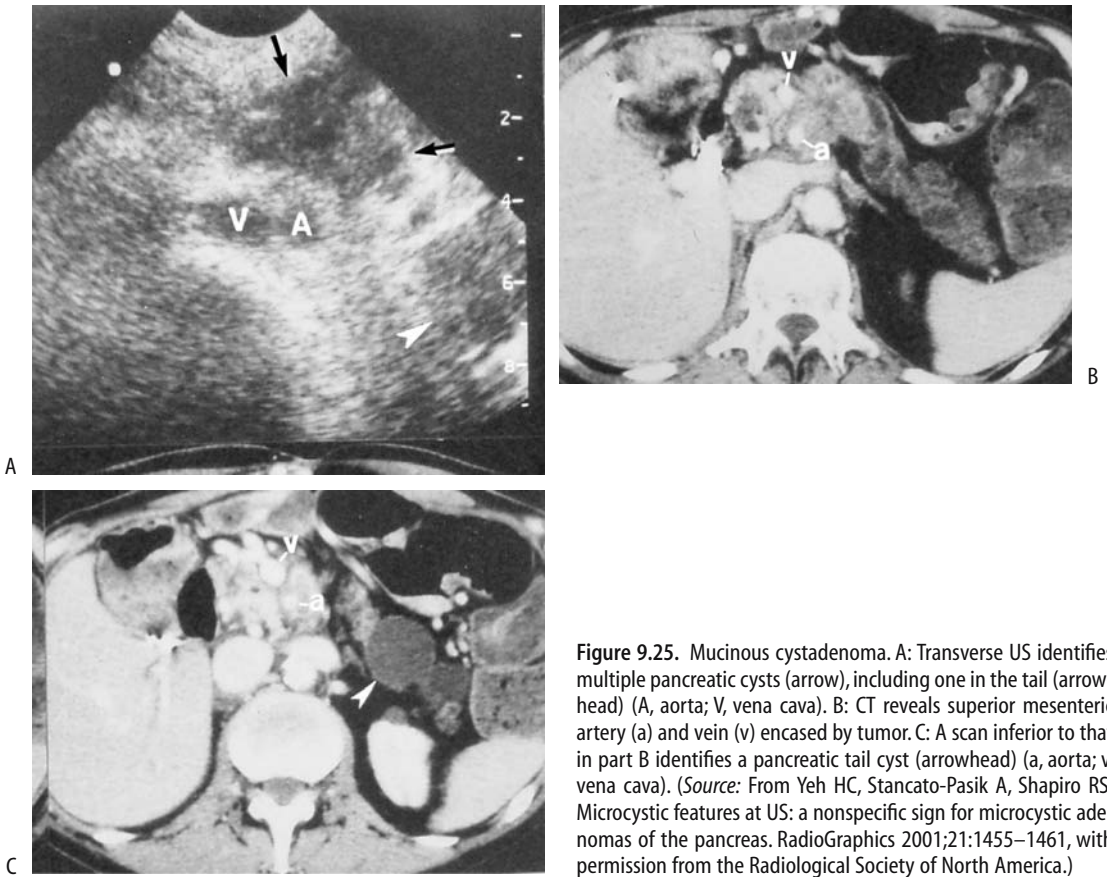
Mucinous cystadenoma. A: Transverse US identifies multiple pancreatic cysts (arrow), including one in the tail (arrowhead) (A, aorta; V, vena cava). B: CT reveals superior mesenteric artery (a) and vein (v) encased by tumor. C: A scan inferior to that in part B identifies a pancreatic tail cyst (arrowhead) (a, aorta; v, vena cava). (Source: From Yeh HC, Stancato-Pasik A, Shapiro RS. Microcystic features at US: a nonspecific sign for microcystic adenomas of the pancreas. *RadioGraphics* 2001;21:1455–1461, with permission from the Radiological Society of North America.)
